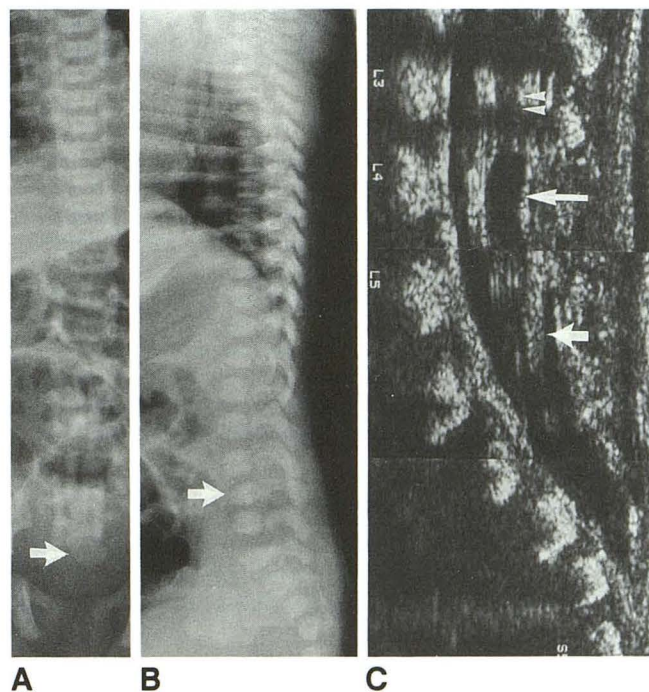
Newborn boy with multiple congenital abnormalities. A frontal radiograph of the spine (A) demonstrates an abnormally large and asymmetric fifth sacral vertebral body (arrow). The lower lumbar vertebral bodies are obscured by an umbilical cord clamp. A lateral plain film (B) shows a kyphosis at L-4 (arrow). Sonography of the spine (C) shows a low conus medullaris (double arrow) at L3–4 with a sonolucent collection at the tip, representing a cerebrospinal fluid cyst (long arrow) and a thickened filum terminale (short arrow) in a dural sac, which ends at S3–4. The final diagnosis was trisomy 13. The child died of muscle weakness and apnea.
